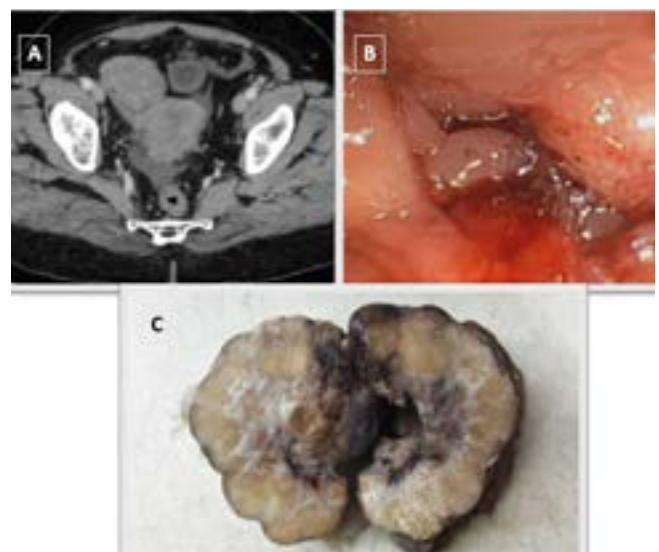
(A) CT abdomen images of Krukenberg tumor revealing enhancing solid asymmetrical adnexal masses with smooth surface. (B) Colonoscopy showing obstructive growth in descending colon. (C) The cut section of the Krukenberg tumor reveals a pale, solid structure. Note the lobulated yet smooth surface of the mass (C belongs to a different patient).
